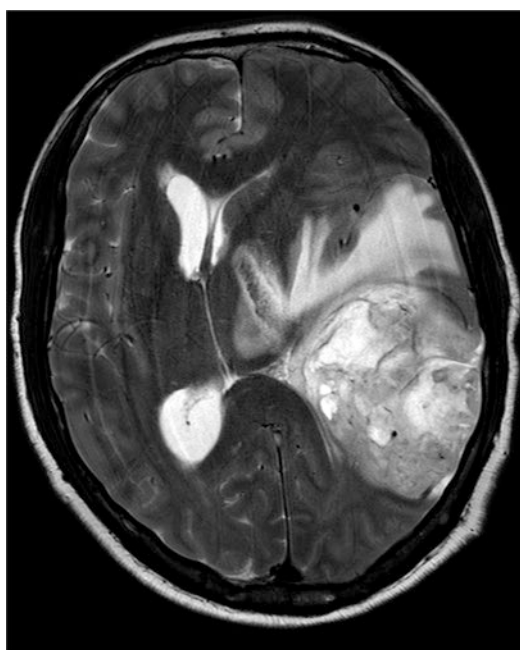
Large well-defined supratentorial space-occupying lesion appearing heterogeneously hyperintense on T2-weighted axial images in the left parietotemporal region with significant perilesional edema, effacement of left ventricle causing midline shift toward the right side
